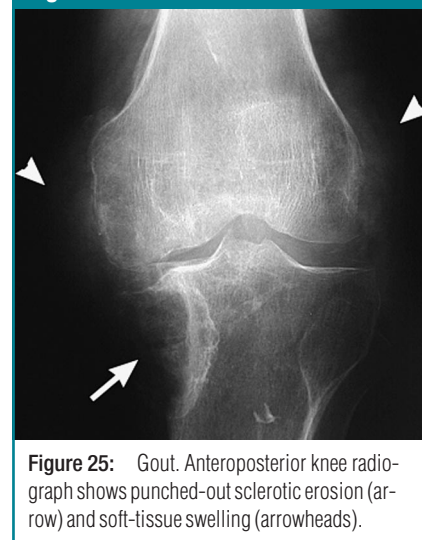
Gout. Anteroposterior knee radiograph shows punched-out sclerotic erosion (arrow) and soft-tissue swelling (arrowheads).
